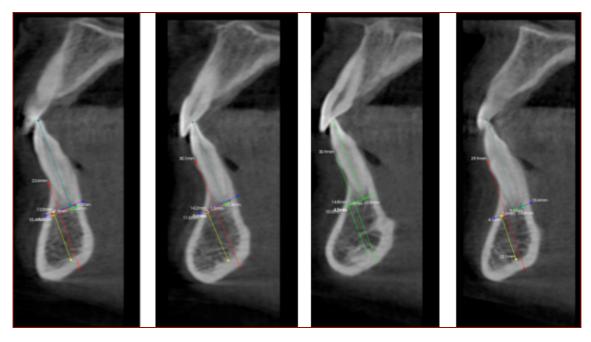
CBCT sagittal sections from patient 1. Incisors 32, 31, 41 and 42.
